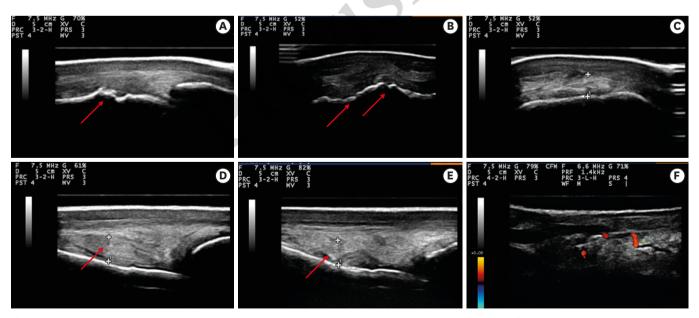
Ultrasound images showing the primary observed changes: osteochondral irregularities in the articular surface of the main metacarpal bone (arrows in A and B); articular capsule heterogeneity (C); increased and heterogeneous plica (arrows in D and E) and synovitis and increased vascularization (F).
